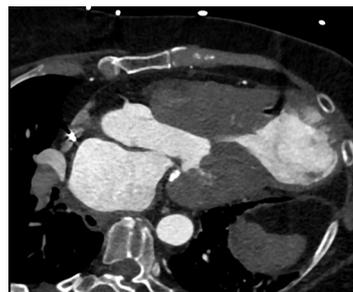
CT cine image of the left ventricle in a three-chamber long axis view demonstrating systolic obliteration of the midventricle and a large apical aneurysm.
